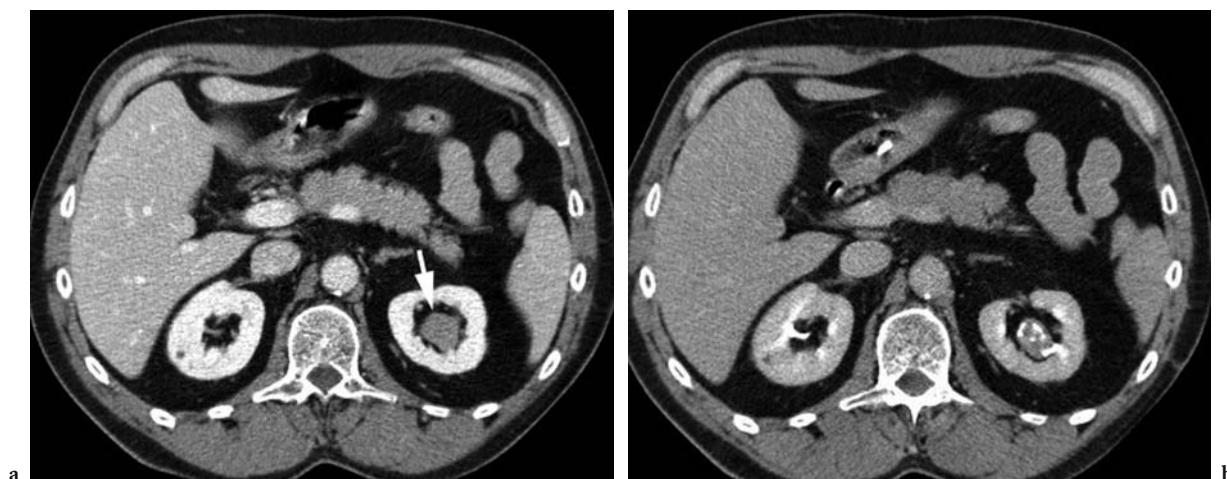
Transitional cell carcinoma in a 65-year-old man with gross painless hematuria. a Axial contrast-enhanced CT scan shows a central lesion in the left kidney (*arrow*) surrounded by renal sinus fat with density higher than urine (30 HU). b Excretory phase CT scan shows contrast filling interstices of tumor of the upper renal pelvis.
